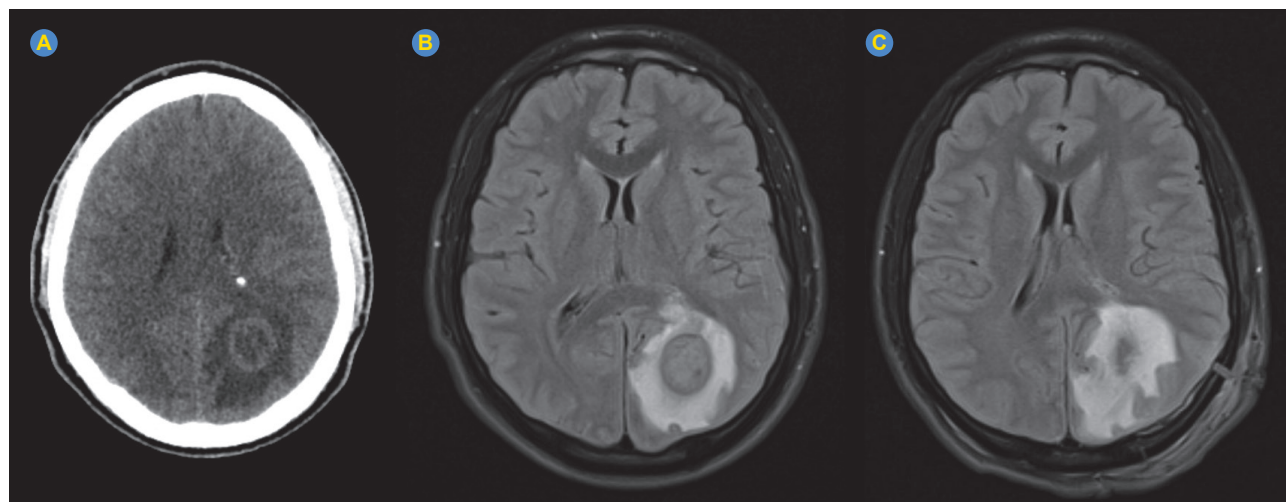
Cerebral CT-scan revealing round lesion with mass effect and edema in the left occipital region (A). Cerebral MRI (T2/FLAIR) revealing a lesion with double rim sign highly characteristic of cerebral abscess (B). Cerebral MRI (T2/FLAIR) three days after surgical drainage (C).
